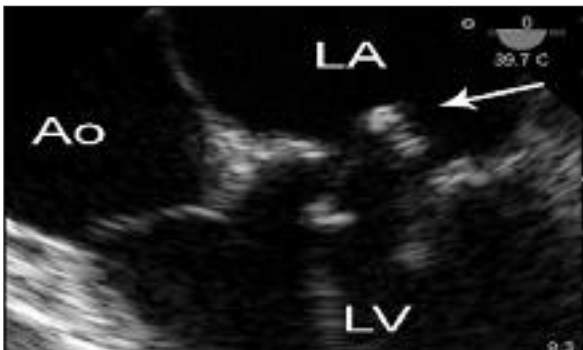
Transesophageal echocardiography showing the torn cusp of the bioprosthetic valve at the mitral position prolapsing into the left atrium as a flail leaflet. Ao: Ascending aorta, LA: Left Atrium, LV: Left Ventricle, Arrow: Flail prolapsing segment of the mitral cusp.
